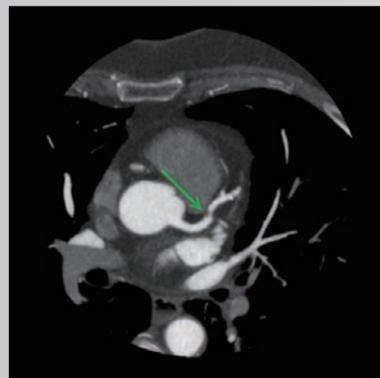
CT coronary angiogram. BMI 26. Critical LAD stenosis (arrow). Dose 0.8 mSv.
